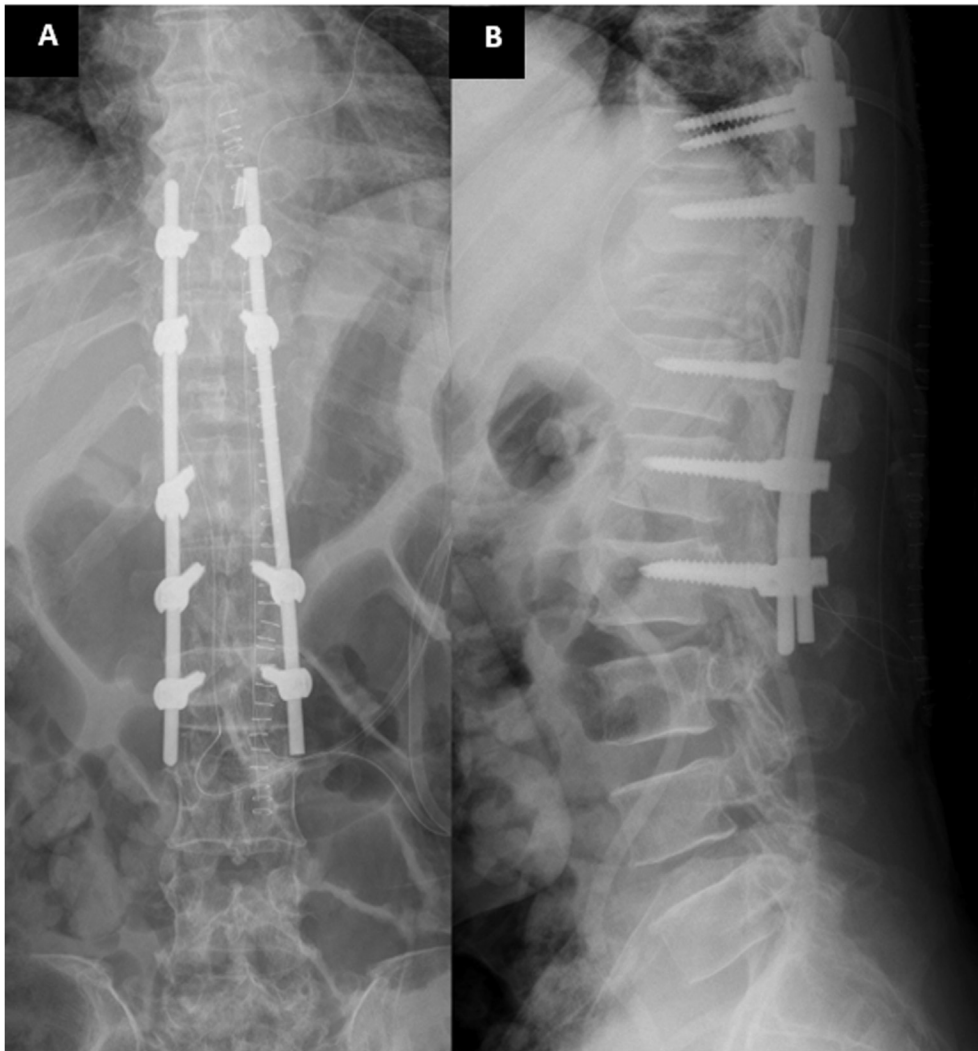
A. Postoperative anteroposterior radiograph. B. Lateral radiograph. Posterior instrumented fusion was done.
